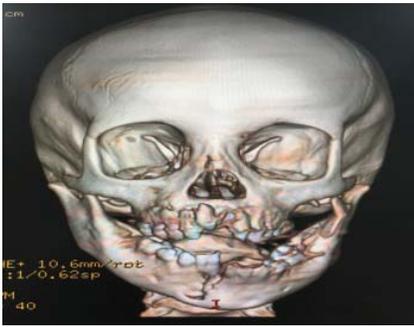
initial Maxillofacial 3D CT scan
